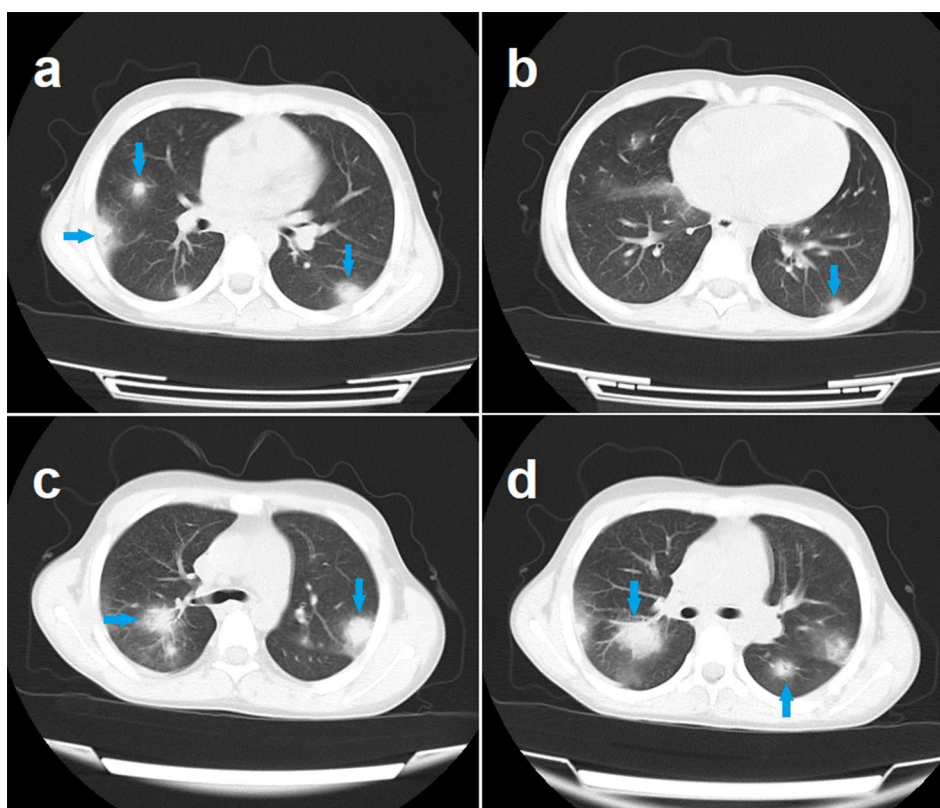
a-d Chest spiral computed tomography (CT) without contrast demonstrated multiple bilateral nodules of varying sizes, each surrounded by a halo sign. This radiological finding is highly suggestive of an infectious process, most likely an invasive fungal infection
